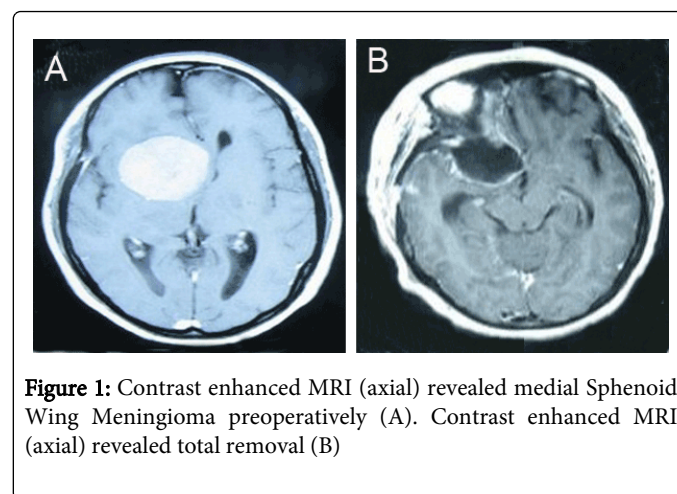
Contrast enhanced MRI (axial) revealed medial Sphenoid Wing Meningioma preoperatively (A). Contrast enhanced MRI (axial) revealed total removal (B)
